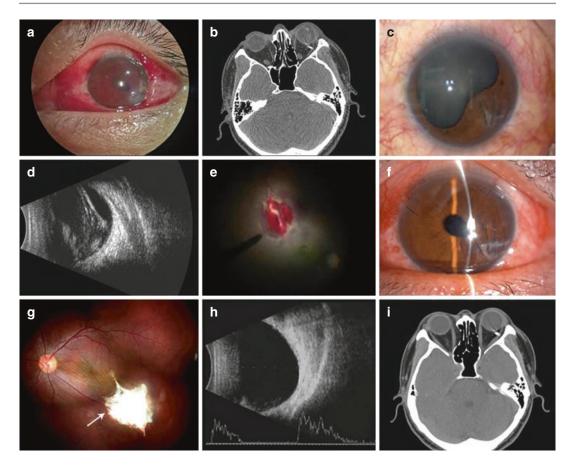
(a) A 43-year-old man injured by an iron dust on left eye during mechanical work with the vision of light perception. Slit-lamp examination revealed a 3 mm full-thickness irregular corneal laceration inferotemporal with iris incarcerated in the corneal wound. (b) The emergency orbital CT demonstrated a metallic foreign body in the orbit of the left eye. (c) The corneal wound healed well with posterior synechia of iris 10 days after the emergency surgery. (d) The dense vitreous hemorrhage was shown by ocular
